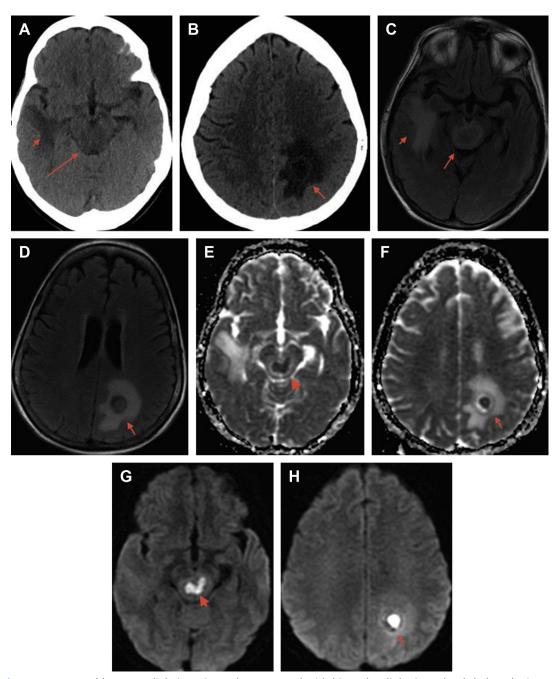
A 58-year-old woman dialysis patient who presented with binocular diplopia and ophthalmoplegia. Patient could not receive contrast due to elevated creatine and poor renal function. (A, B) Axial CT scans at level of cerebral peduncles and left parietal lobe with arrowhead and arrows denoting areas of decreased attenuation consistent with edema. Note the faint rim of increased attenuation from abscess rim within the left parietal edema. (C, D) Corresponding axial fluid-attenuated inversion recovery (FLAIR) MR imaging with hyperintense FLAIR signal (edema) surrounding foci of decreased attenuation (abscesses) (arrow). (E-H) MR imaging, ADC and DWI. Arrows and arrowhead denote restricted diffusion of the abscess within the brainstem and left parietal lobe with dark ADC and hyperintense DWI signal.
